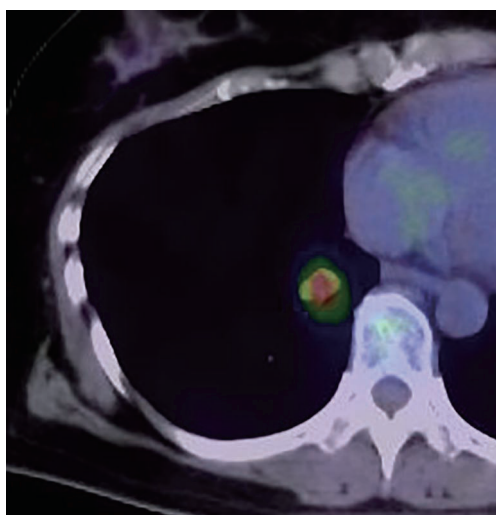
FDG-PET scan showing an SUVmax of 9.05 in the tumor. FDG-PET, 18-fluorodeoxyglucose positron emission tomography.
